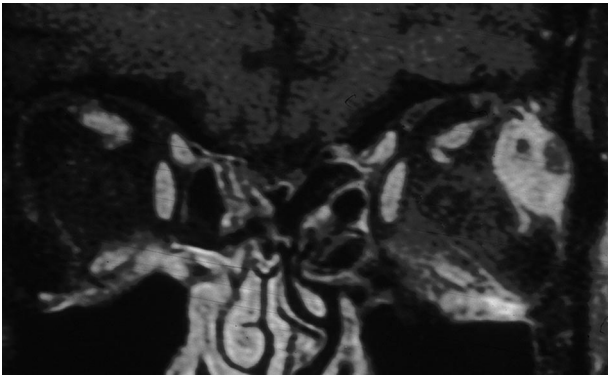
Coronal MRI shows a mass with several cystic areas involving the lacrimal gland.
